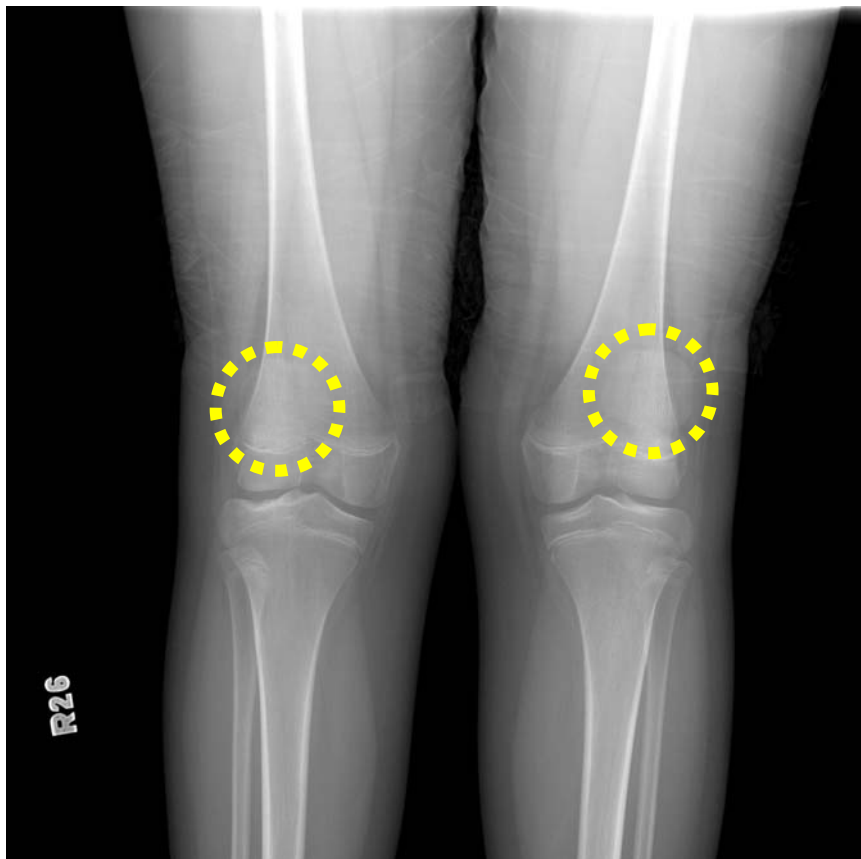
November 5, 2015 knee X-ray standing: bilateral patellar subluxation
